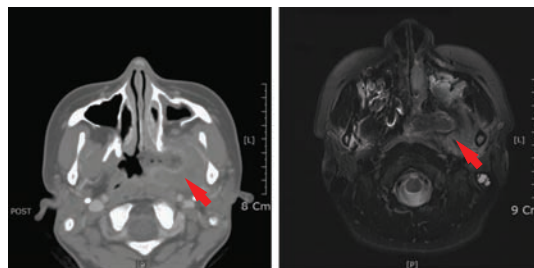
Preoperative facial CT and PNS MRI showing a hypodense inflamed lesion. CT indicates computed tomography; PNS MRI, paranasal sinus magnetic resonance image.
